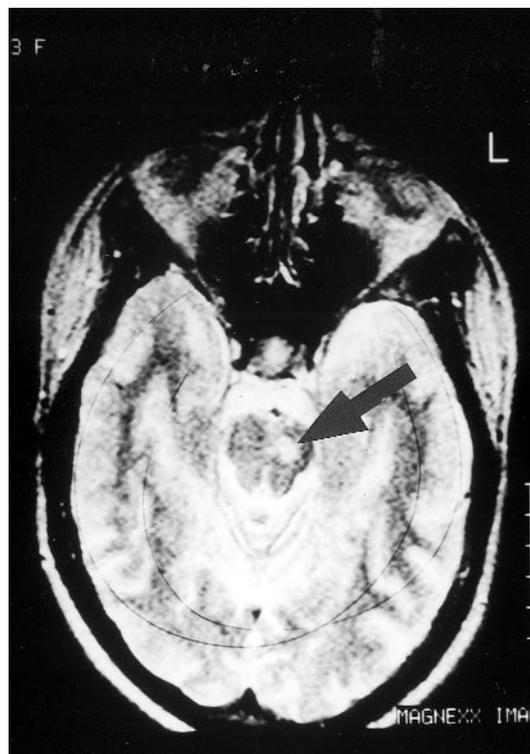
MRI T2 weighted sequence reveals 7 mm rounded focus of increased signal in the upper pons of the lower midbrain.
